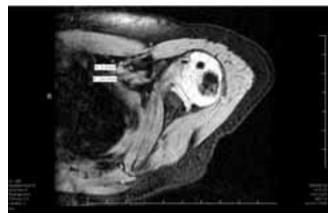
Axial MRI image demonstrating measurement of the glenoid version (-17°) , PHHA (8.8/24.6 = 0.358), and biceps angle (-12°) in a patient with -30 degrees of passive external rotation with the scapula stabilized.
